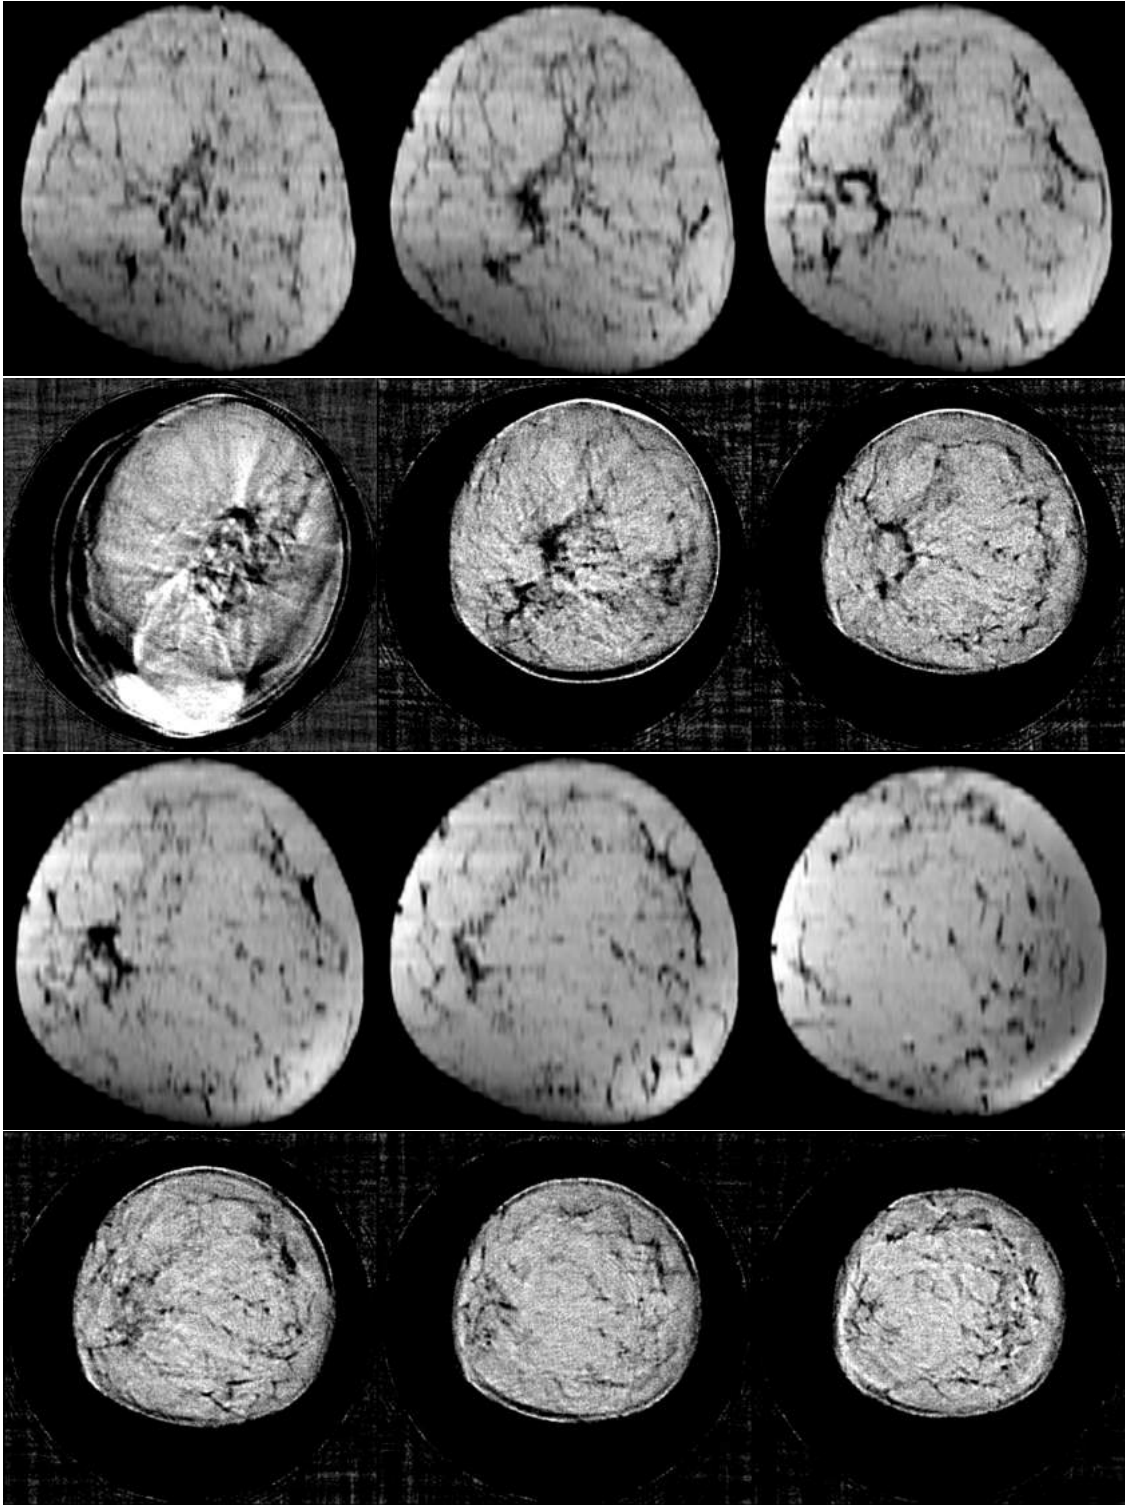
Comparison of Waveform Tomography Reconstruction to MRI. Combinations of numbers and arrows indicate the corresponding tissues for comparison. Data was acquired by the new prototype. Gray scale values of the waveform tomography image have been inverted to better match the MR image. (a) Waveform sound speed; (b) Corresponding MRI slice; (c) Waveform sound speed; (d) Corresponding MRI slice.
